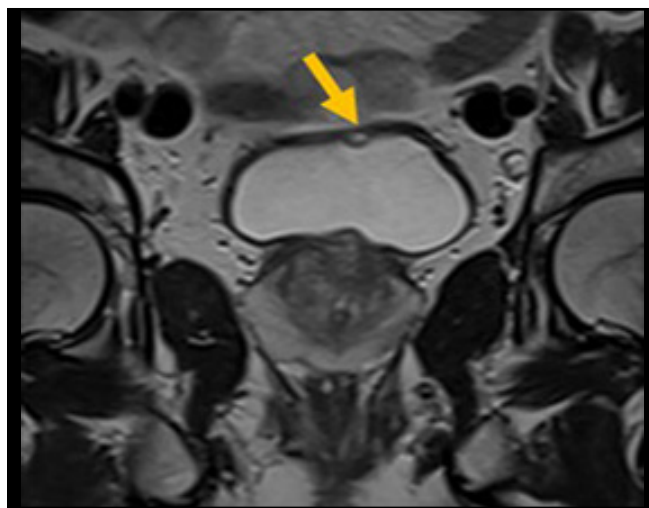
The lesion was same in size and signal intensity on pelvic MRI that was performed 10 months before (yellow arrow).
